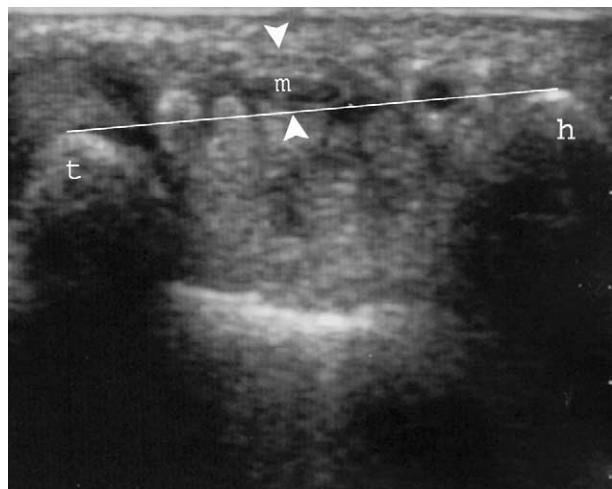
Sonograms of a symptomatic CTS patient. (a) The median nerve of normal size at the proximal level (7 mm<sup>2</sup>). (b) At the pisiform level the size of the median
